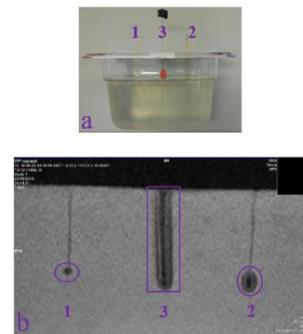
(a) Three core needles, FB based needles no. 1 & 2 placed on the sides while the standard core needle is located in middle, (b) MRI image of cores.
